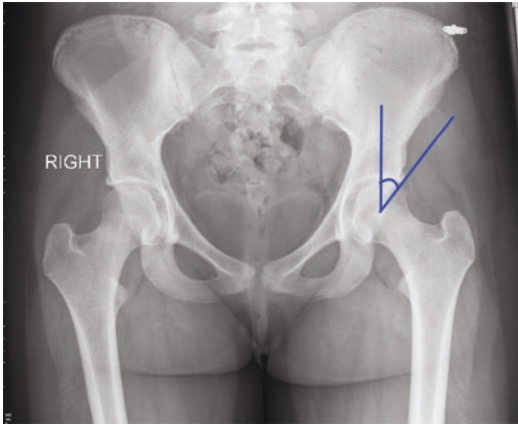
AP radiograph is shown for a patient with mixed type FAI and increased lateral overcoverage of the acetabulum. The LCEA is measured with the vertex of the angle at the center of the femoral head, the vertical limb perpendicular to the horizontal and the second limb tangent to the lateral-most aspect of the acetabular rim
